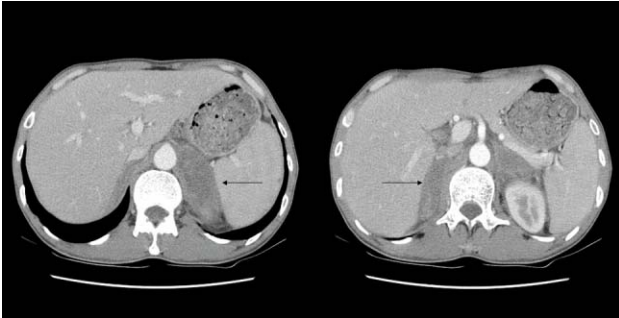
CT of abdomen revealed bilateral adrenal masses with central necrosis.
